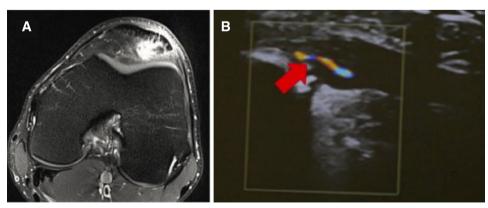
Radiographical appearance of chronic patellar tendinopathy. (A) MRI showing enhanced signal intensity in T2 sequences near the distal pole of patella with thickening of the tendon at this level. (B) Colour Doppler mode ultrasound (US) showing neovascularisation (arrow) of the proximal patellar tendon. Reprinted with permission from Zayni *et al*,¹⁵ 2015.
